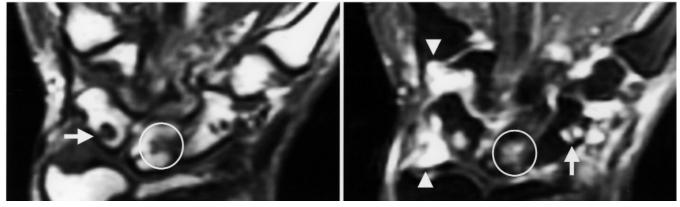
Representative MR images of patients with early-stage RA. T1-weighted spin-echo images show bone edema (circle), bone erosion (arrow), and synovitis (arrowheads). Right panel: gadolinium-diethylenetriamine-enhanced image.
